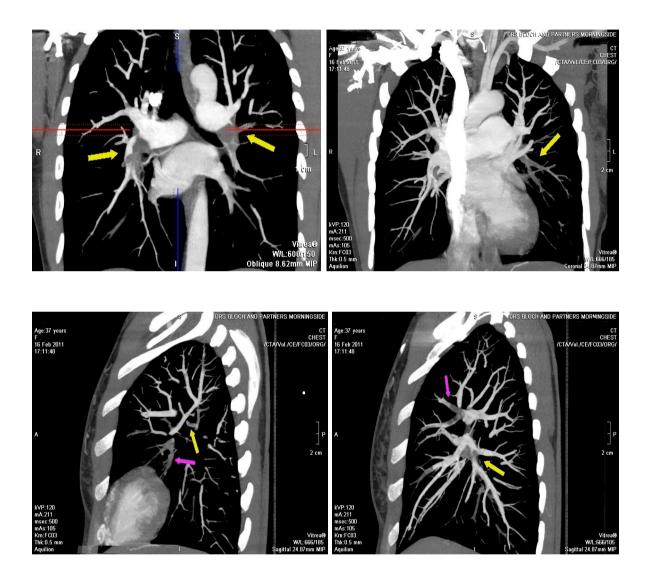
A series of four Chest CT Scan images demonstrating a massive PE in a 37 year old female presenting with acute onset of dyspnoea. Permission granted from Drs Bloch and Partners Morningside MediClinic Radiology Department.
